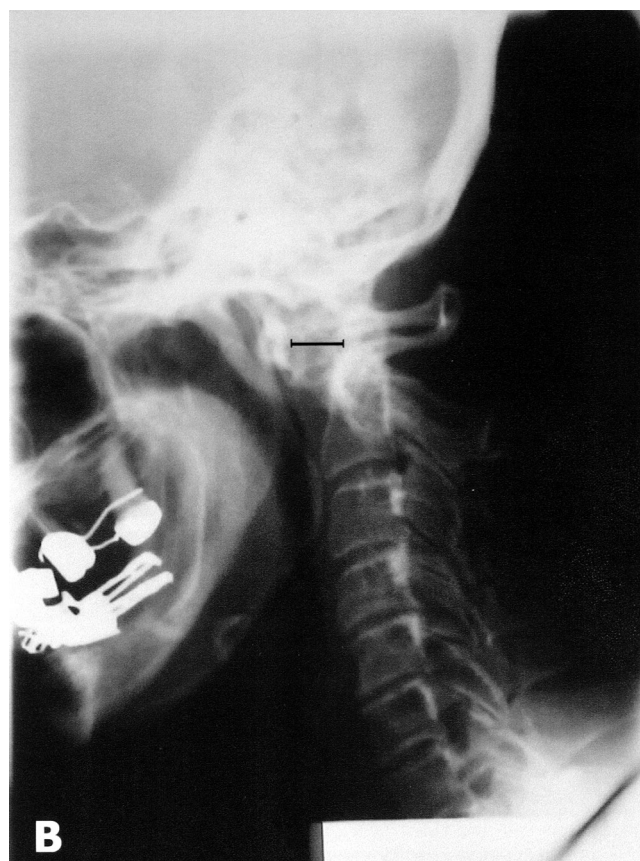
A 62-year-old patient with a 12 year history of RA with neck pain, without neurological signs. Lateral radiographs show (A) in neutral position, normal atlas-dental interval; (B) in flexion position, a 12 mm AAS (black line).
